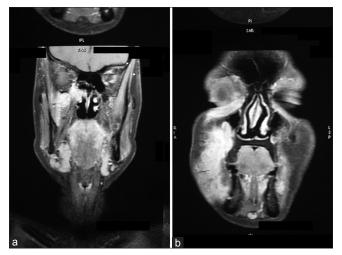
(a and b) Computed tomography contrast showing lesion over the right buccal space region
